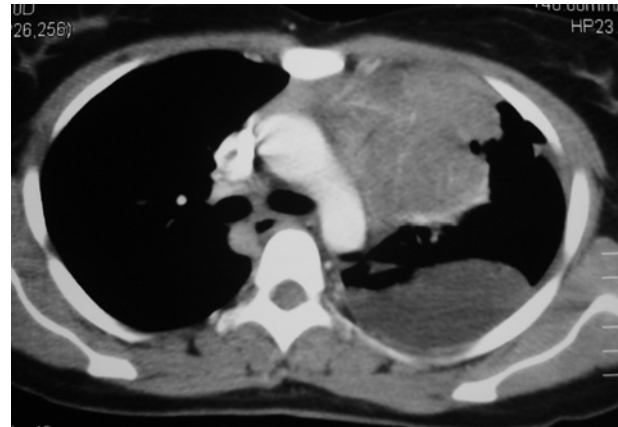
CT scan of chest showing mediastinal mass in lymphoma with pleural effusion.
